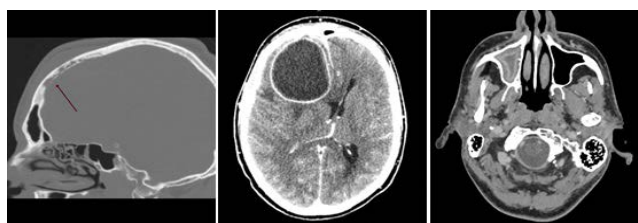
Preoperative sagittal and axial CT-Scan (case 2) shows a frontal osteitis (red arrow), a voluminous frontal cerebral abscess with a mass effect on the lateral ventricle and deviation of the mid-line, as well as a full right-sided maxillary opacity.
